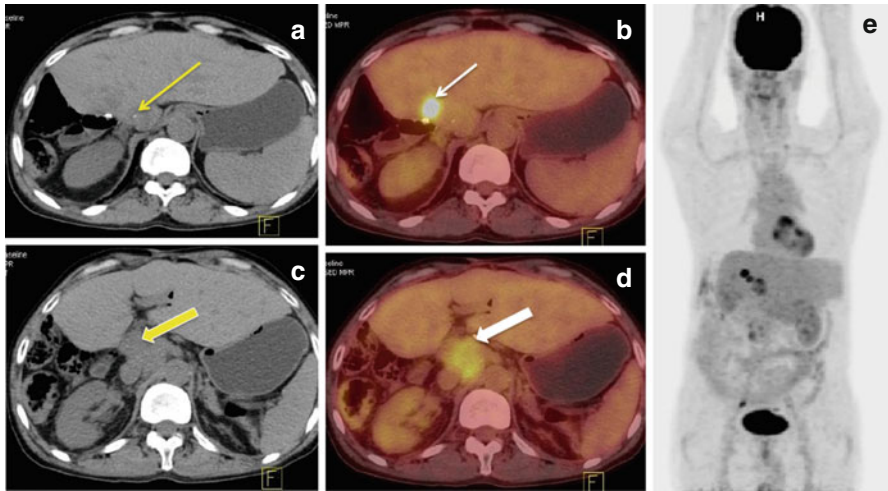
PET-CT in a postoperative case of hilar cholangiocarcinoma revealed recurrent disease involving the liver (yellow and white straight arrow; a, b) and abdomino-pelvic lymph nodes (yellow and white block arrows; c, d)
